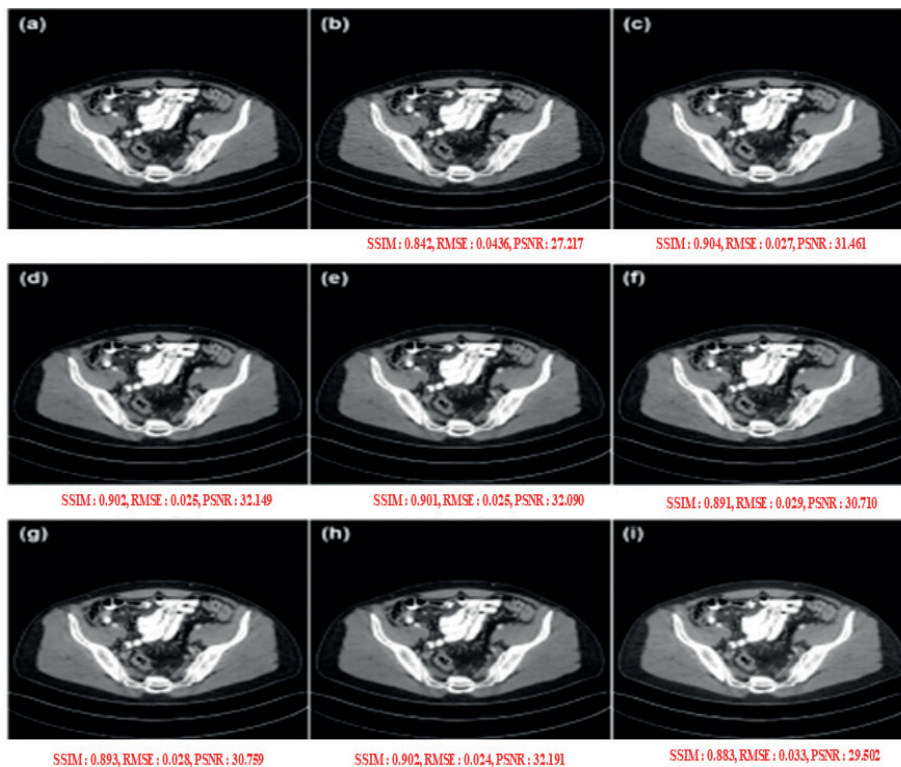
Quantitative Investigation of the noise-reduction capabilities of the CT dataset using the provided method's framework and a variety of various predictor possibilities (a) CT Dose of 25 Milligrams (b) Proposed model-Unet (c) Proposed model-DnCNN (d) Proposed model -SRDenseNet (e) Proposed model -U+D (f) Proposed model
